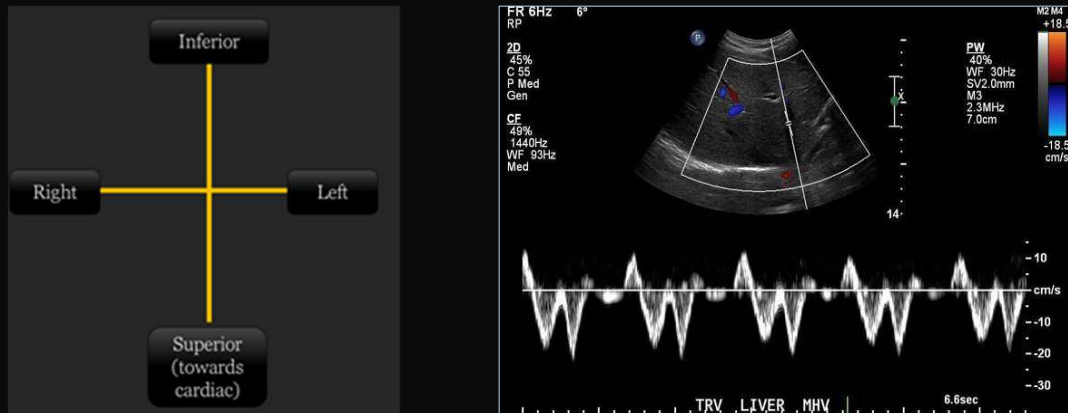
2. Iranpour, P, et.al. Altered Doppler flow patterns in cirrhosis patients: an overview.
